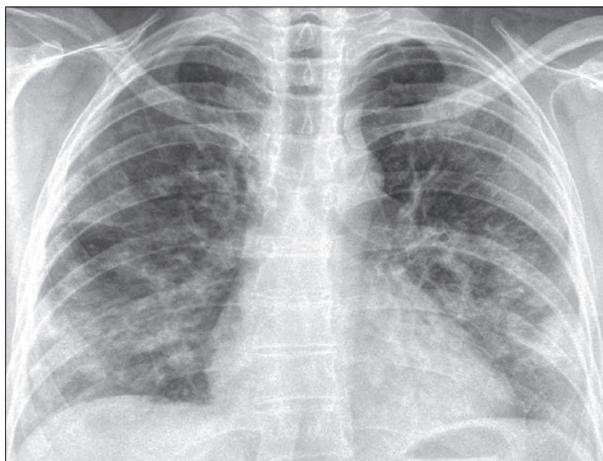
Follow-up chest X-ray now showing the changes initially seen only on the computed tomography scan
